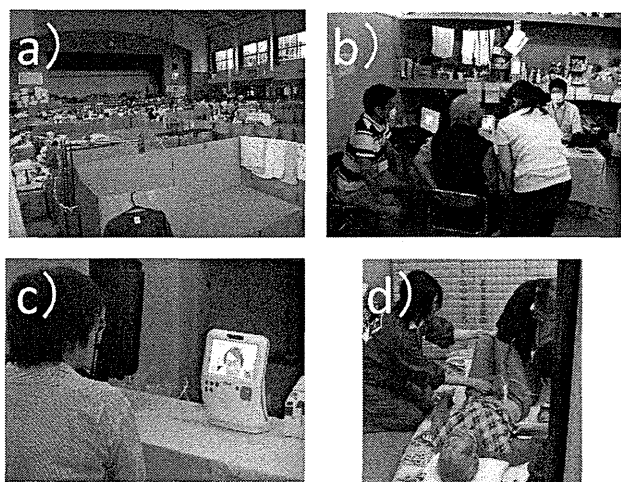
Application of the proposed system at the shelter using a gymnasium in Kesenuma. a) Whole view of the shelter, b) Remote consultation assisted by a nurse, c) Conversation between a patient and a doctor far from there with Skype terminals, d) Use of an ultra-compact ultrasonographic unit.
